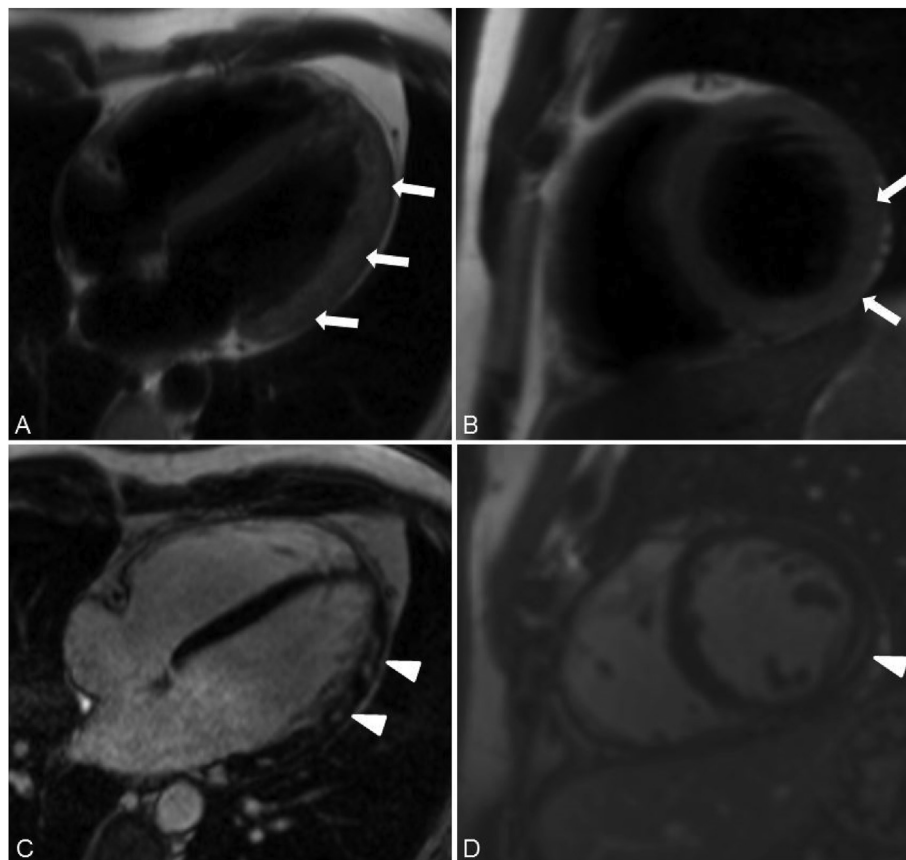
Cardiac MRI demonstrated lateral ventricular wall edema in T2-weighted images (A, B, arrows) with corresponding LGE in T1-weighted images (C, D, arrowheads) indicating acute myocarditis. In four-chamber view (Figure 2 A and B) spotty hyper hyperintensities corresponding to the lateral ventricular edema are confirming the diagnosis. Besides from these findings, indicating myocarditis, our cardiac MRI showed no other pathologies and physiological anatomy.
